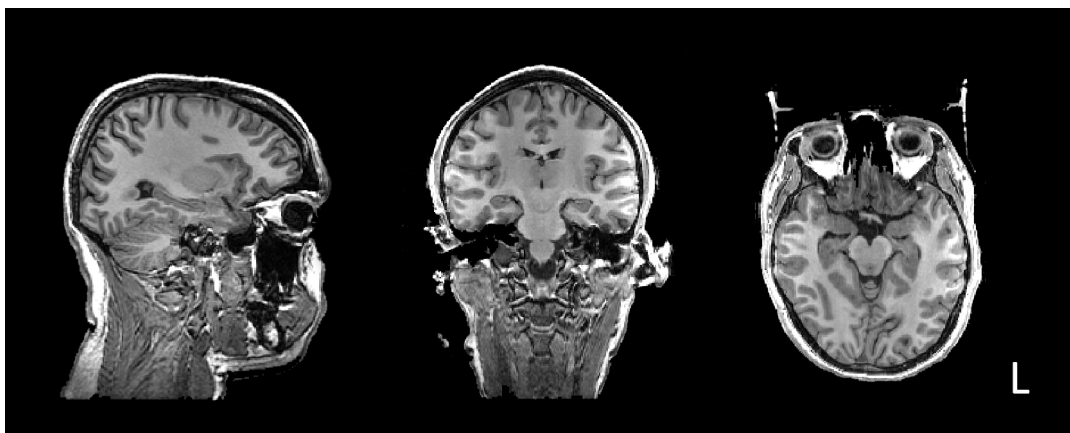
High-resolution T1-weighted image of a subject in our experiment.
